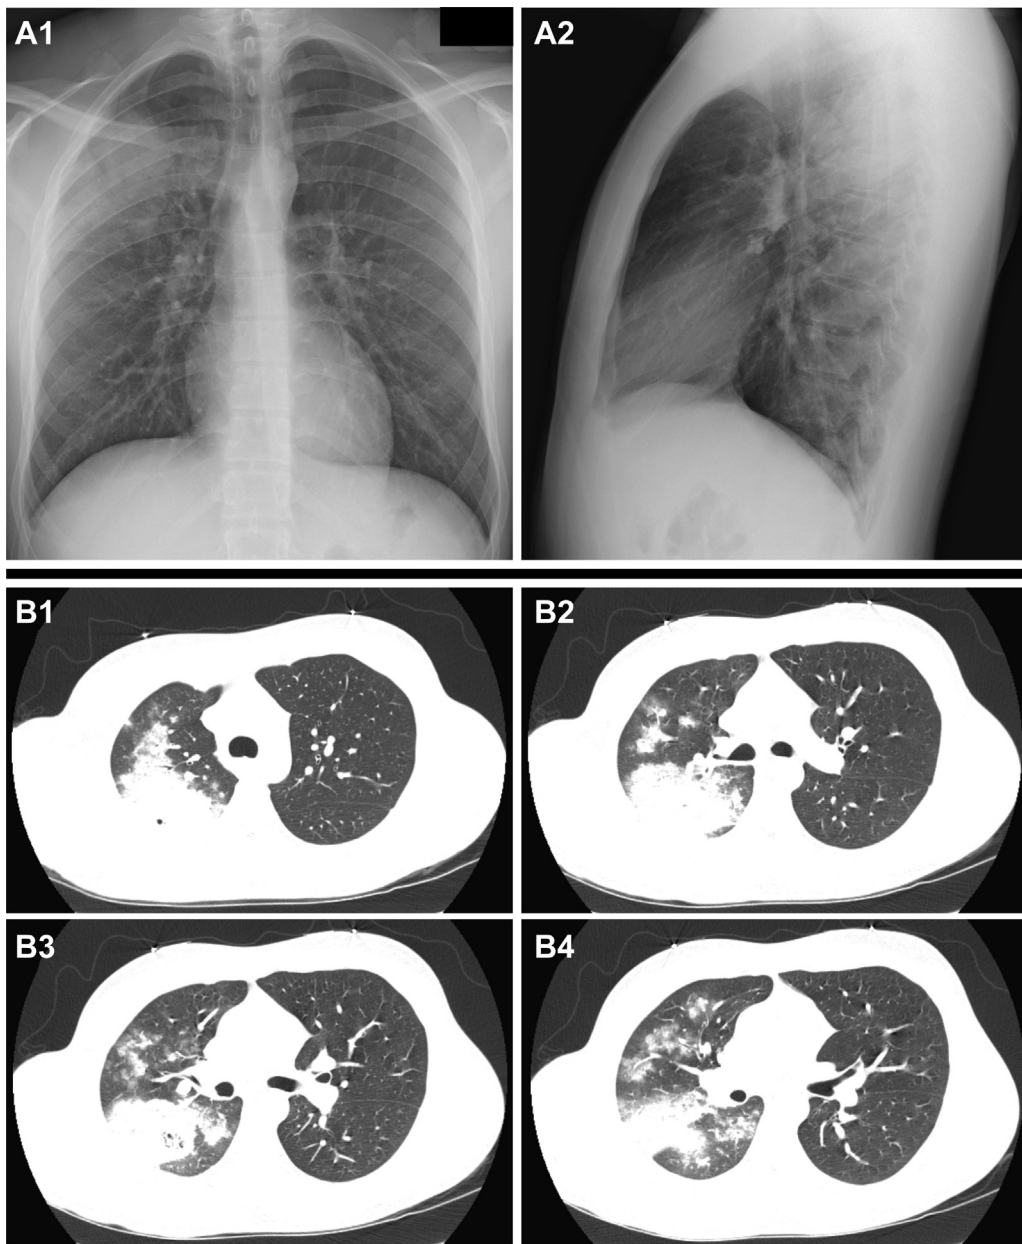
A1-A2, Anteroposterior and lateral chest radiographs on admission. B1-B4, Chest CT scan on admission.
